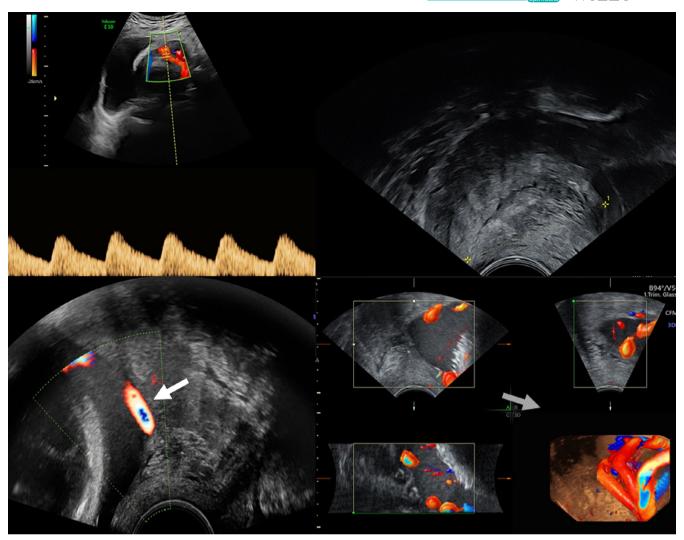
Case 2: Fetal vessels presenting between fetal head and cervix (transabdominal with color-coded Doppler ultrasound, transvaginal with and without color-coded Doppler ultrasound). Velamentous insertion of vessels (white arrow)—3D mapping of fetal vessels causing vasa previa (grey arrow)
